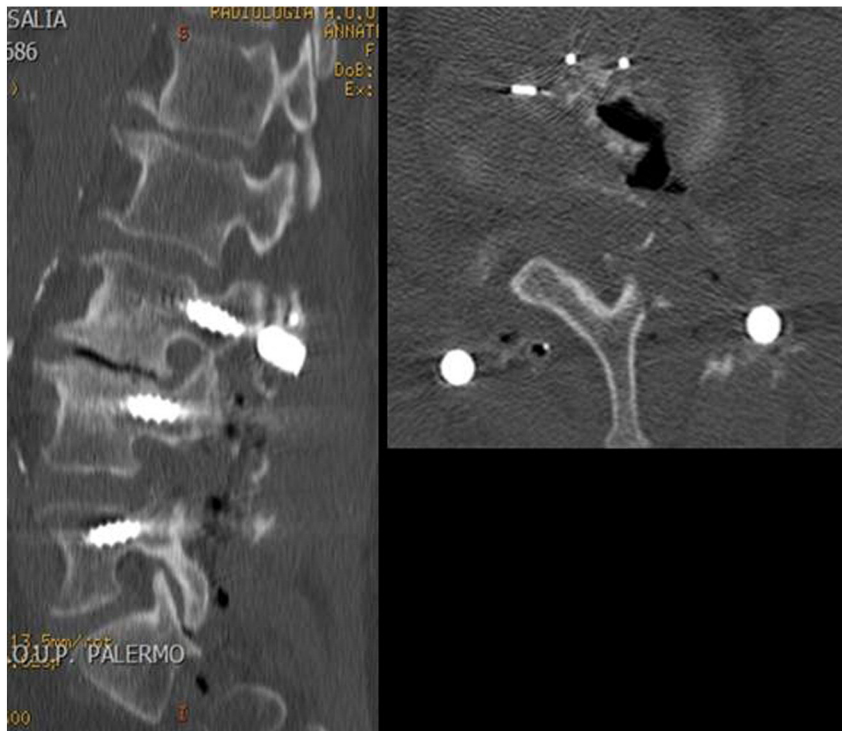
Post-operative lumbar CT scan. Pedicle screws in L3, L4 and L5 bilaterally and intersomatic L4–L5 cage by TLIF.
